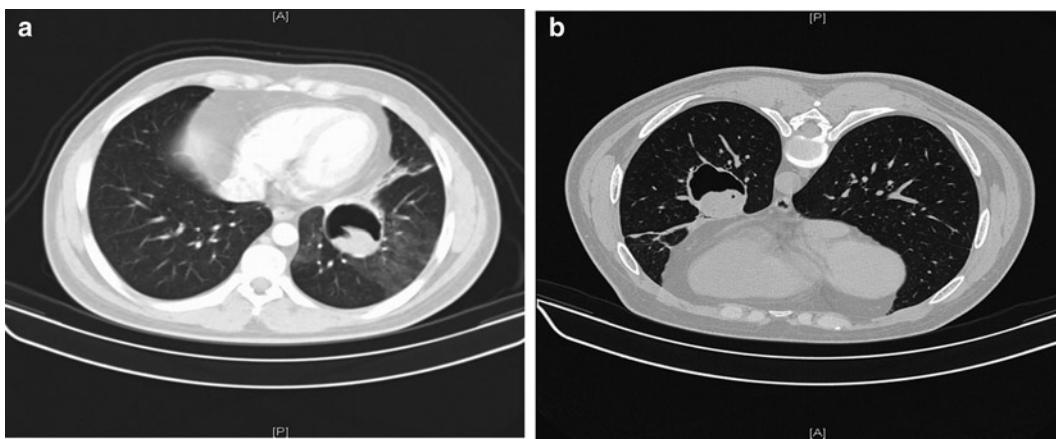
Hydatid cyst mimicking a fungal ball in the left chest. (a) Supine and (b) prone CT images. Note that the contents of the cyst have moved with the position of the patient.
